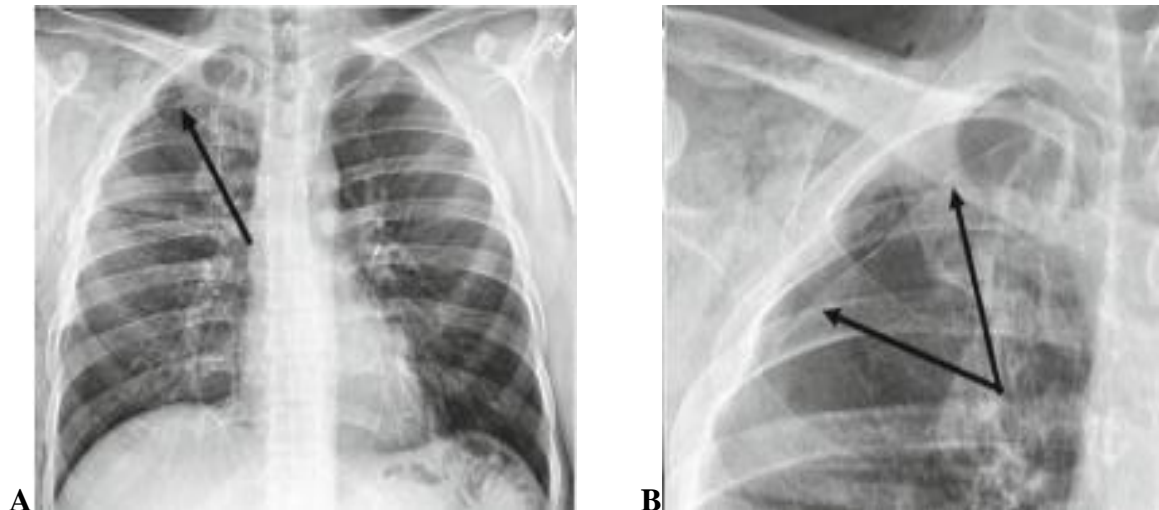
Pneumothorax. (A) Frontal chest radiograph. (B) Spot film of right side chest. Note how the edge of the collapsed right lung is delineated by a sharply demarcated thin white line (arrows), the visceral pleura, beyond which no pulmonary markings are identified (best seen on close up image on right)
